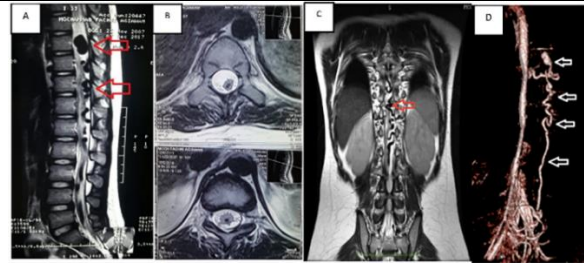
(A) MRI of the thoracolumbar T2 sequences before embolization. Sagittal slice. (B) Axial view of the T2 sequences MRI of the thoracolumbal. (C) MRI of thoracolumbar T2 sequences before embolization of coronal slice. (D) Congestive perimedullary
